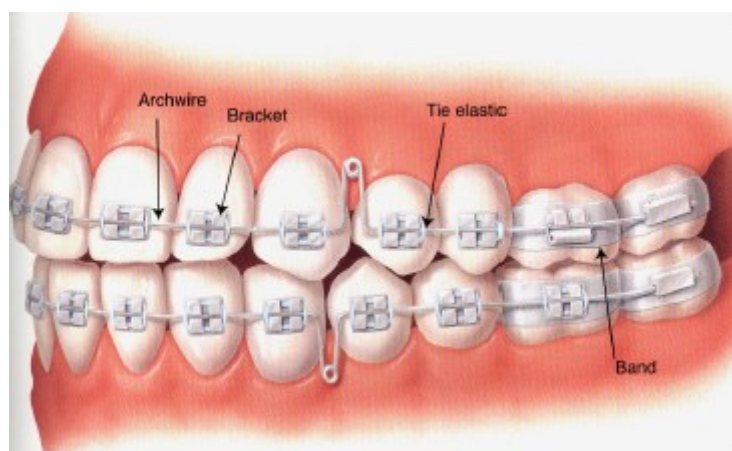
Fixed orthodontic appliances. They cannot be removed during MRI [Staley and Reske, 2013].
